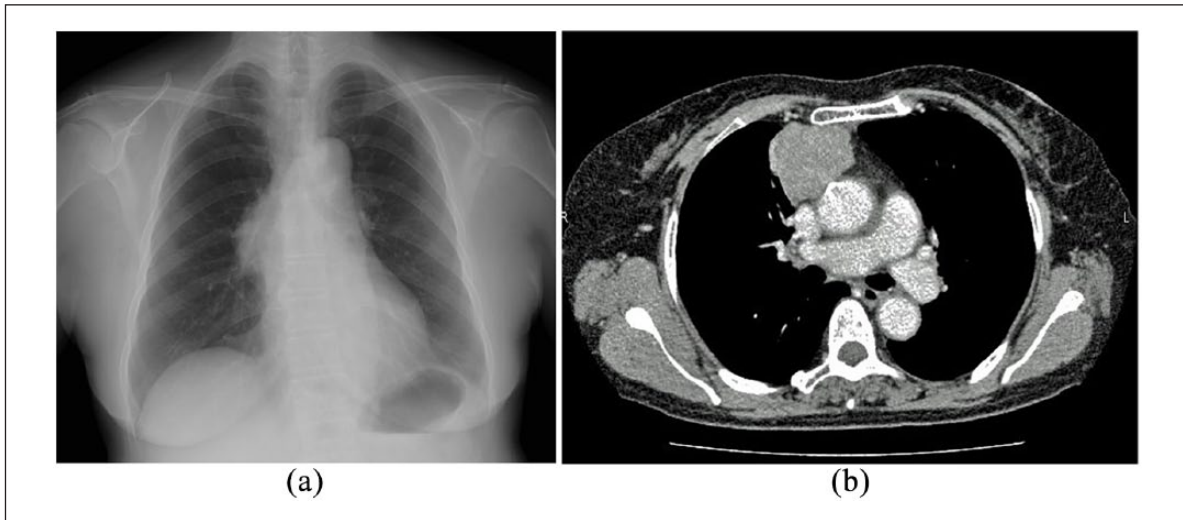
(a) A chest roentgenogram shows a tumor mass of the right pulmonary hilum and (b) a chest computed tomography scan shows the lesion, measuring 45 mm × 45 mm, is adjacent to the superior vena cava and the ascending aortic with a homogeneous inner component in the right anterior mediastinum.
